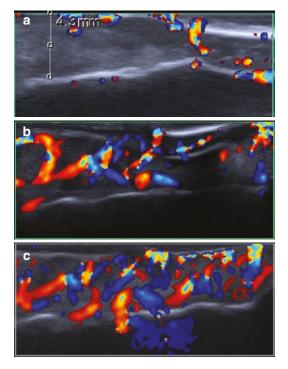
(a) US image of donor area in the palate before FGG. (b) US image of donor area in the palate 2 weeks after FGG (without PRF placement as a dressing). (c). US image of donor area in the palate 2 weeks after FGG (with PRF placement as a dressing). Doppler imaging revealed intensity of vascularization
